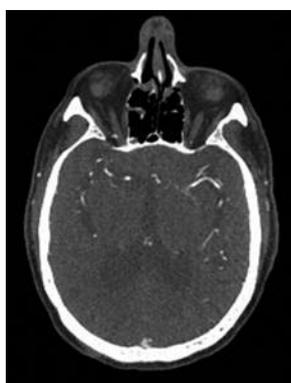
Definition Flash-CT showing the cerebral arteries.
